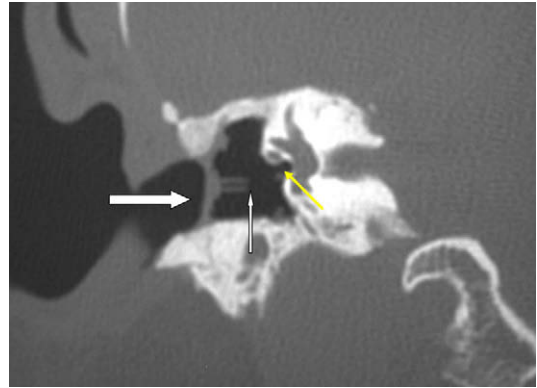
Coronal CT image following mastoidectomy and tympanoplasty. Note the thickened lateralized TM/graft (*thick white arrow*) with the caudal portion in particular lateralized. The piston-type partial ossicular prosthesis (*thin white arrow*) has remained with the TM and has been pulled laterally away from the oval window/stapes (*yellow arrow*).
